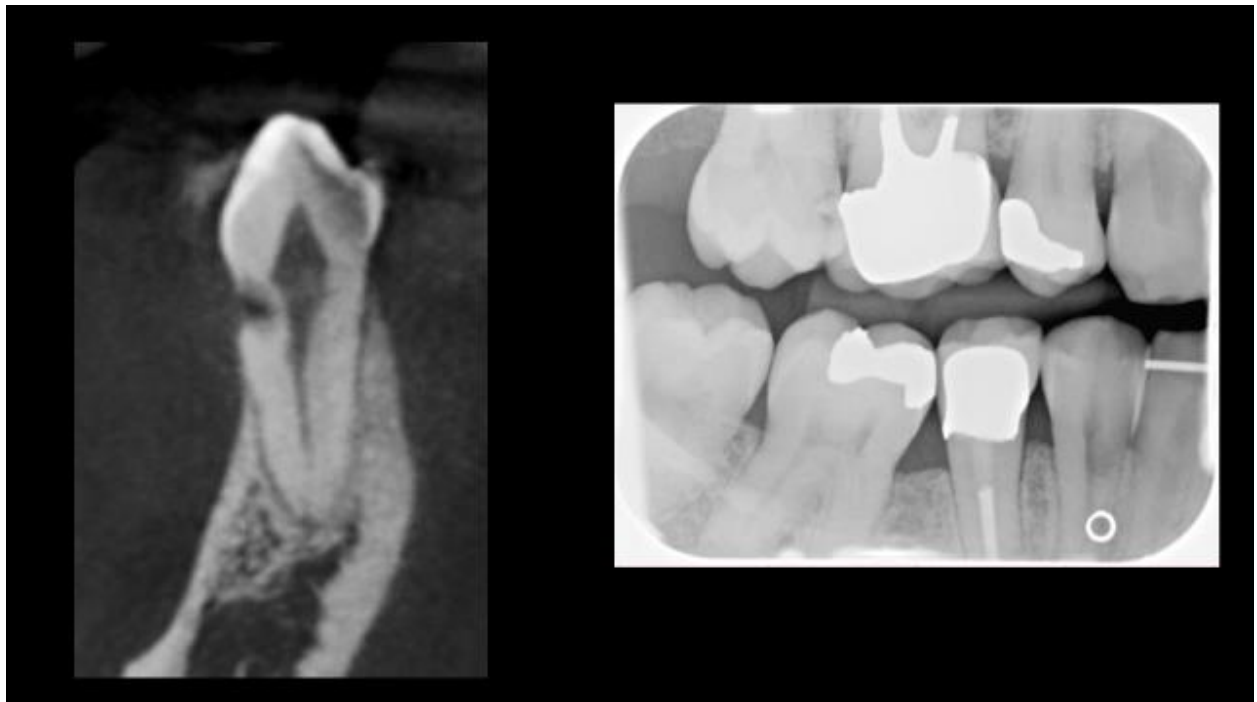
Internal root resorption #28 CBCT (left) visible on PA (right)
